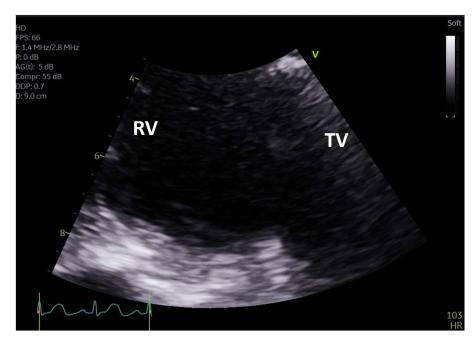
apical 4 chamber and zoomed TV showing persistent leaflet vegetations.
